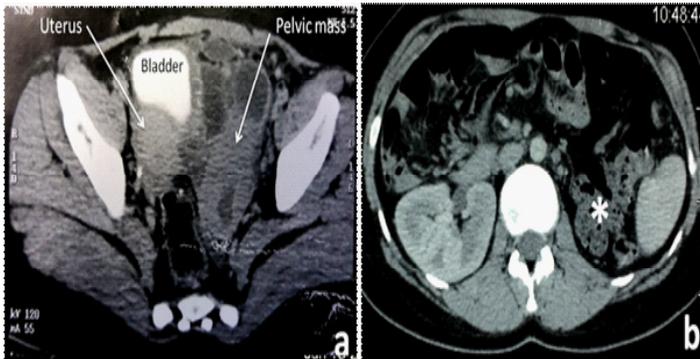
(a) Pelvic Computed tomography scan shows a solid left latero-uterine mass (11 cm in diameter) with cystic component. (b) The left renal lodge * is empty with a compensatory hypertrophy of the right kidney.
